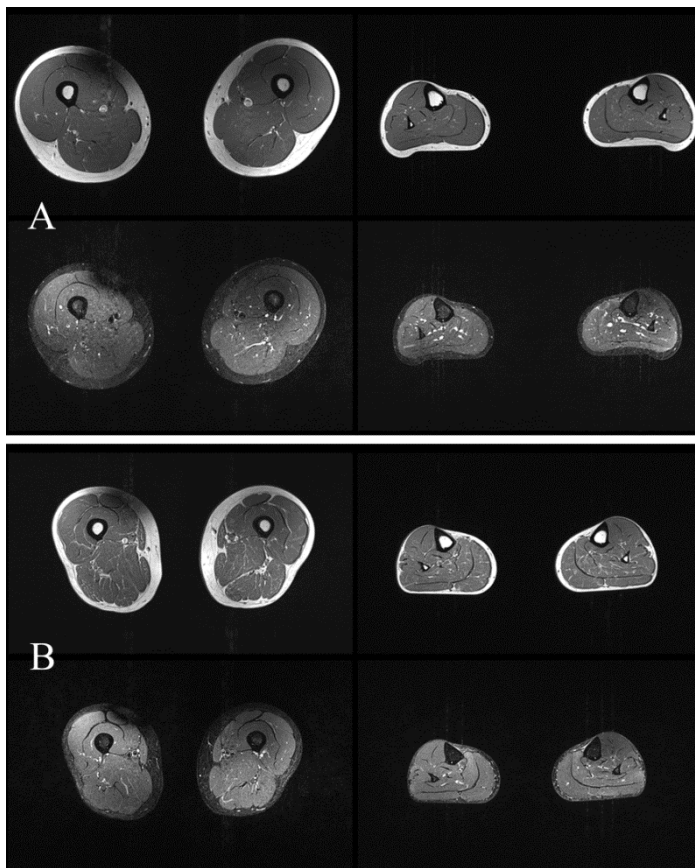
MR images from control subjects: T1w images on the top and STIR images on the bottom row are shown from healthy control subjects with (A) the lowest mean T1 score (subject g) and (B) the highest mean T1 score (subject e). Axial thigh images are shown on the left and calf on the right. On T1w images muscle has a dark grey appearance and fat, as well as bone, is white. On STIR images the fat signal is suppressed and white is indicative of other tissue types with high water content including blood vessels and areas of ‘oedema’ within muscles.
